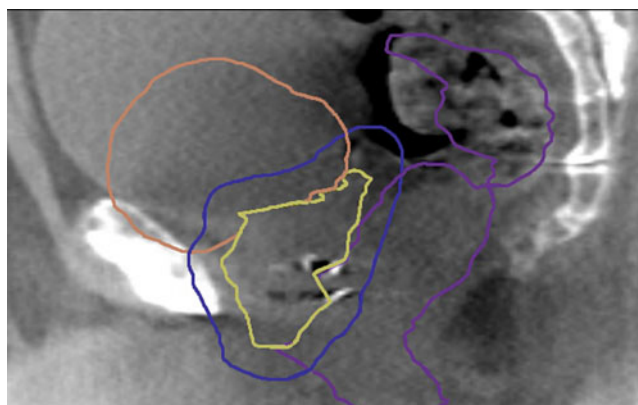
(Colour online) Sagittal CBCT on-treatment image with contours from planning CT overlaid [clinical target volume prostate and seminal vesicles (yellow), planning target volume (blue), bladder (orange) and rectum (purple)]. Increase in bladder volume seen compared to planning with expansion superiorly and anteriorly. Increase in mid/upper rectal volume seen compared to planning due to faeces and gas with expansion anteriorly. Motion results in shift in prostate position compared to planning identified by displacement of fiducial markers.
